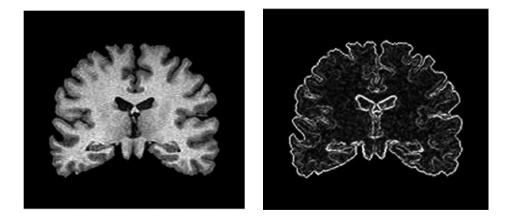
[51]: coronal slice of a T1 weighted cerebral MRI (left) and its corresponding absolute gradient image
